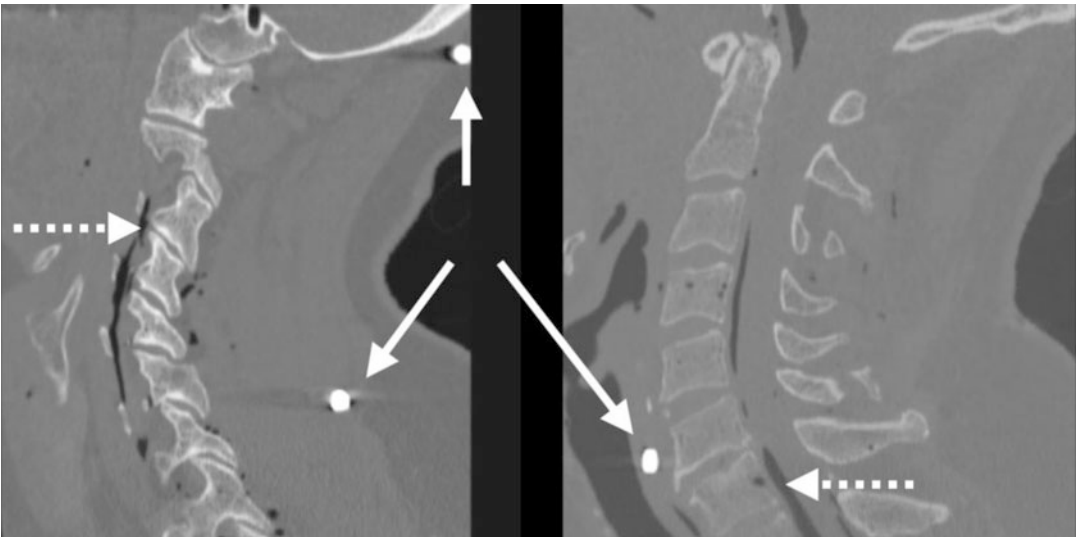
Computed Tomography scans taken after early testing of cylindrical FSPs (*solid arrows*) into the neck of a post mortem human subject demonstrating normal human anatomical relationships. However note inclusion
